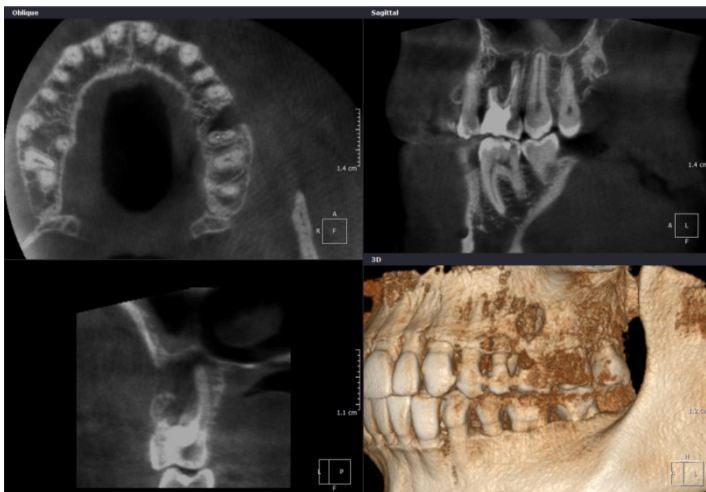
Large periapical lesion associated with the root of the 26 endodontically treated tooth. Imaged with the Scanora 3D (Soredex, Tuusula, Finland) and presented in the On-Demand 3D software (CyberMed, Seoul, South Korea).
